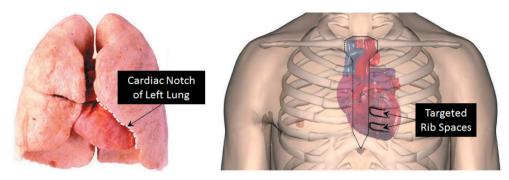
(Left) Cardiac notch of the left lung provides left parasternal access into the anterior mediastinum towards the heart without lung obstruction. (Right) Targeted rib spaces for lead insertion over the cardiac notch of the left lung.
